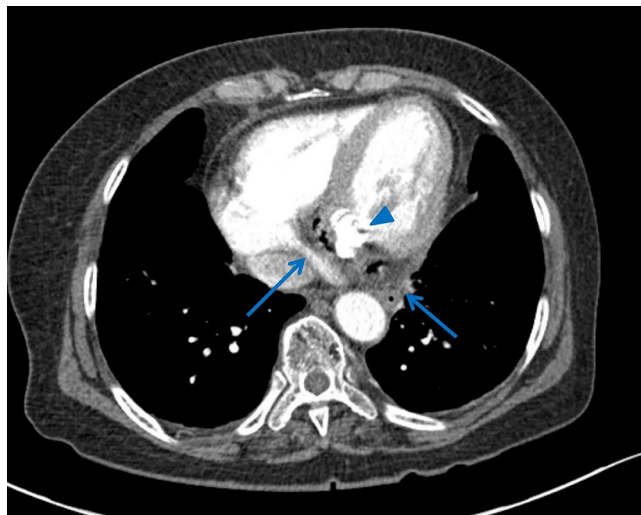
Contrast-enhanced chest computed tomography image revealing abnormal air bubbles with low attenuated lesion (arrows) surrounding the calcified mitral valve annulus (arrowhead)
